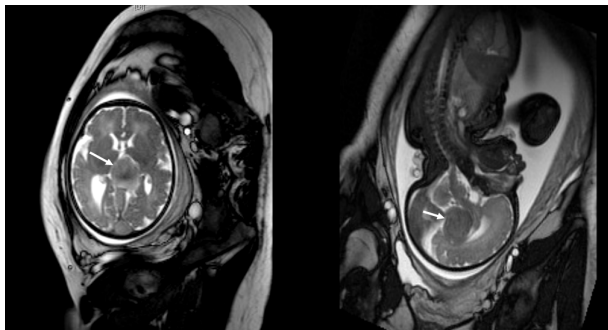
Fetal MRI showing grossly dilated vein of Galen with mild ventriculomegaly and significant dilatation of sinuses.
